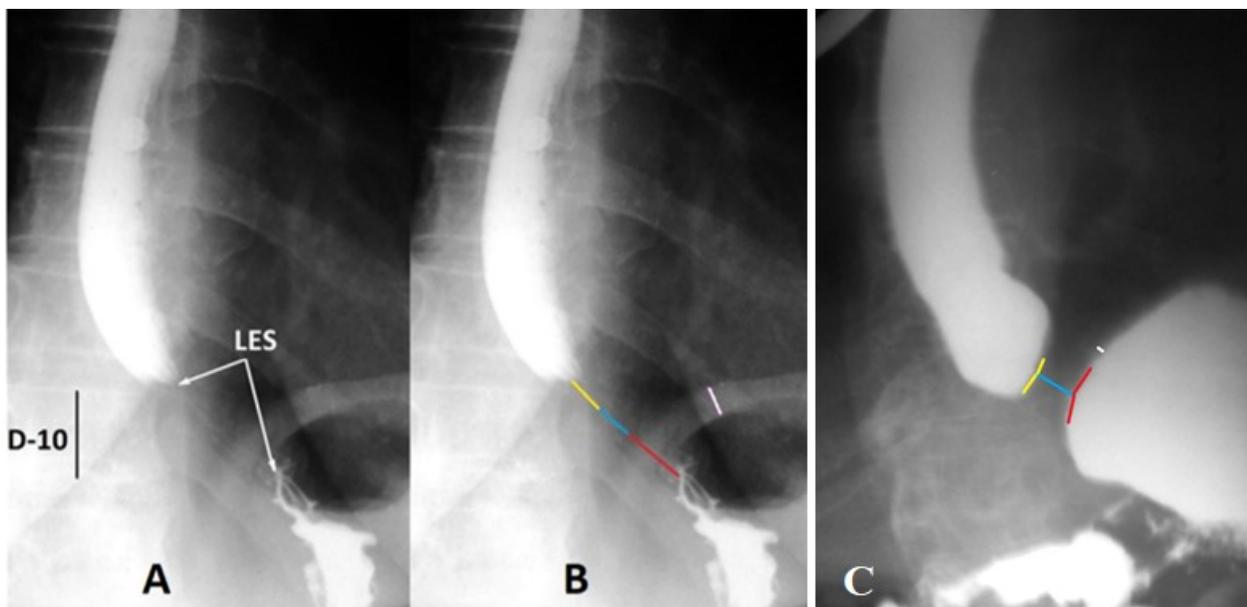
(A) Radiograph of a GEJ in the vertical position of an adult with GERD. The abdomen compression during barium swallowing caused a contraction of the LES. (B) The same radiograph for analysis. Since it is known that the height of the 10th thoracic vertebra (D-10) is ≈ 2 cm, we calculated the length of the LES (3.3 cm), the length of the intra-abdominal part (red line - 1.3 cm), at the level diaphragm (blue line - 1 cm), above the diaphragm (yellow line - 1 cm). The thickness of the stomach wall (white line) is 0.7 cm. The shortening of the LES occurred due to the shortening of the abdominal portion of the LES (1.3 cm versus 2.1 cm). The image shows 2 folds of the open portion of the abdominal portion of the LES caudally to redline. (C) In a horizontal position, after taking a large amount of barium during abdominal compression, the pressure in the stomach increased (stomach wall thickness decreased), which led to an additional opening of the LES. The length of the gap
